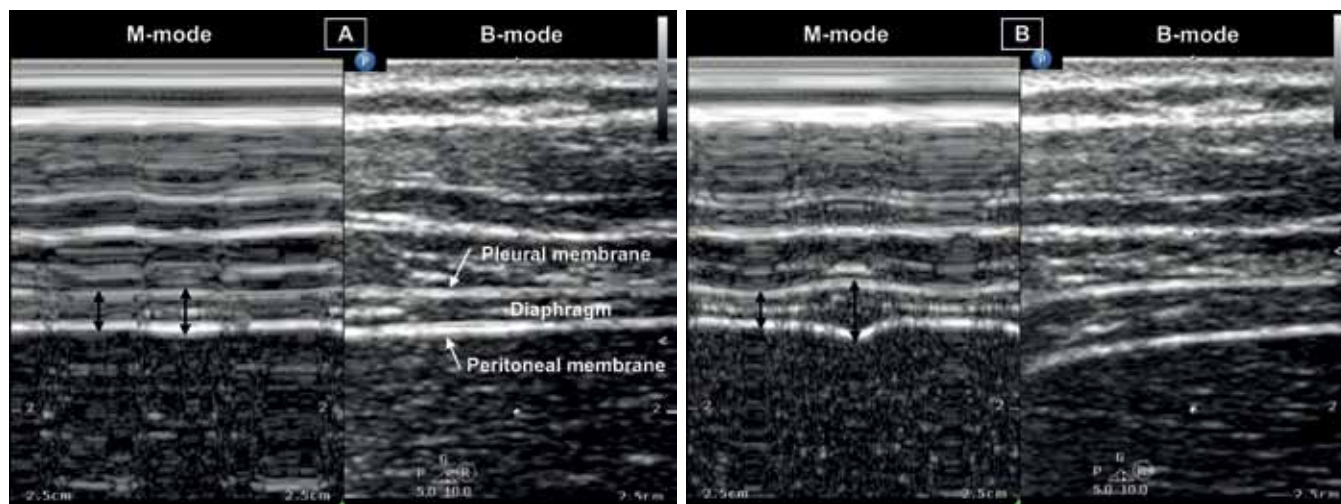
B-mode (right) and M-mode (left) ultrasound images of the diaphragm, measured at the zone of apposition. Measurements of the thickness (black vertical lines) during expiration (left) and inspiration (right). Figure A shows reduced diaphragm contractile activity with a small change in thickness during inspiration (thickening fraction = 13%), Figure B shows adequate diaphragm contractile activity with a larger change in thickness during inspiration (thickening fraction = 70%).
